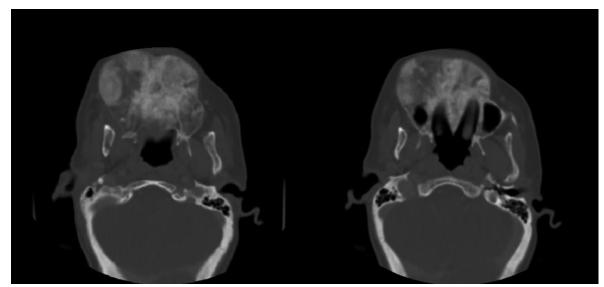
CT at axial view showing the extension of the lesion
